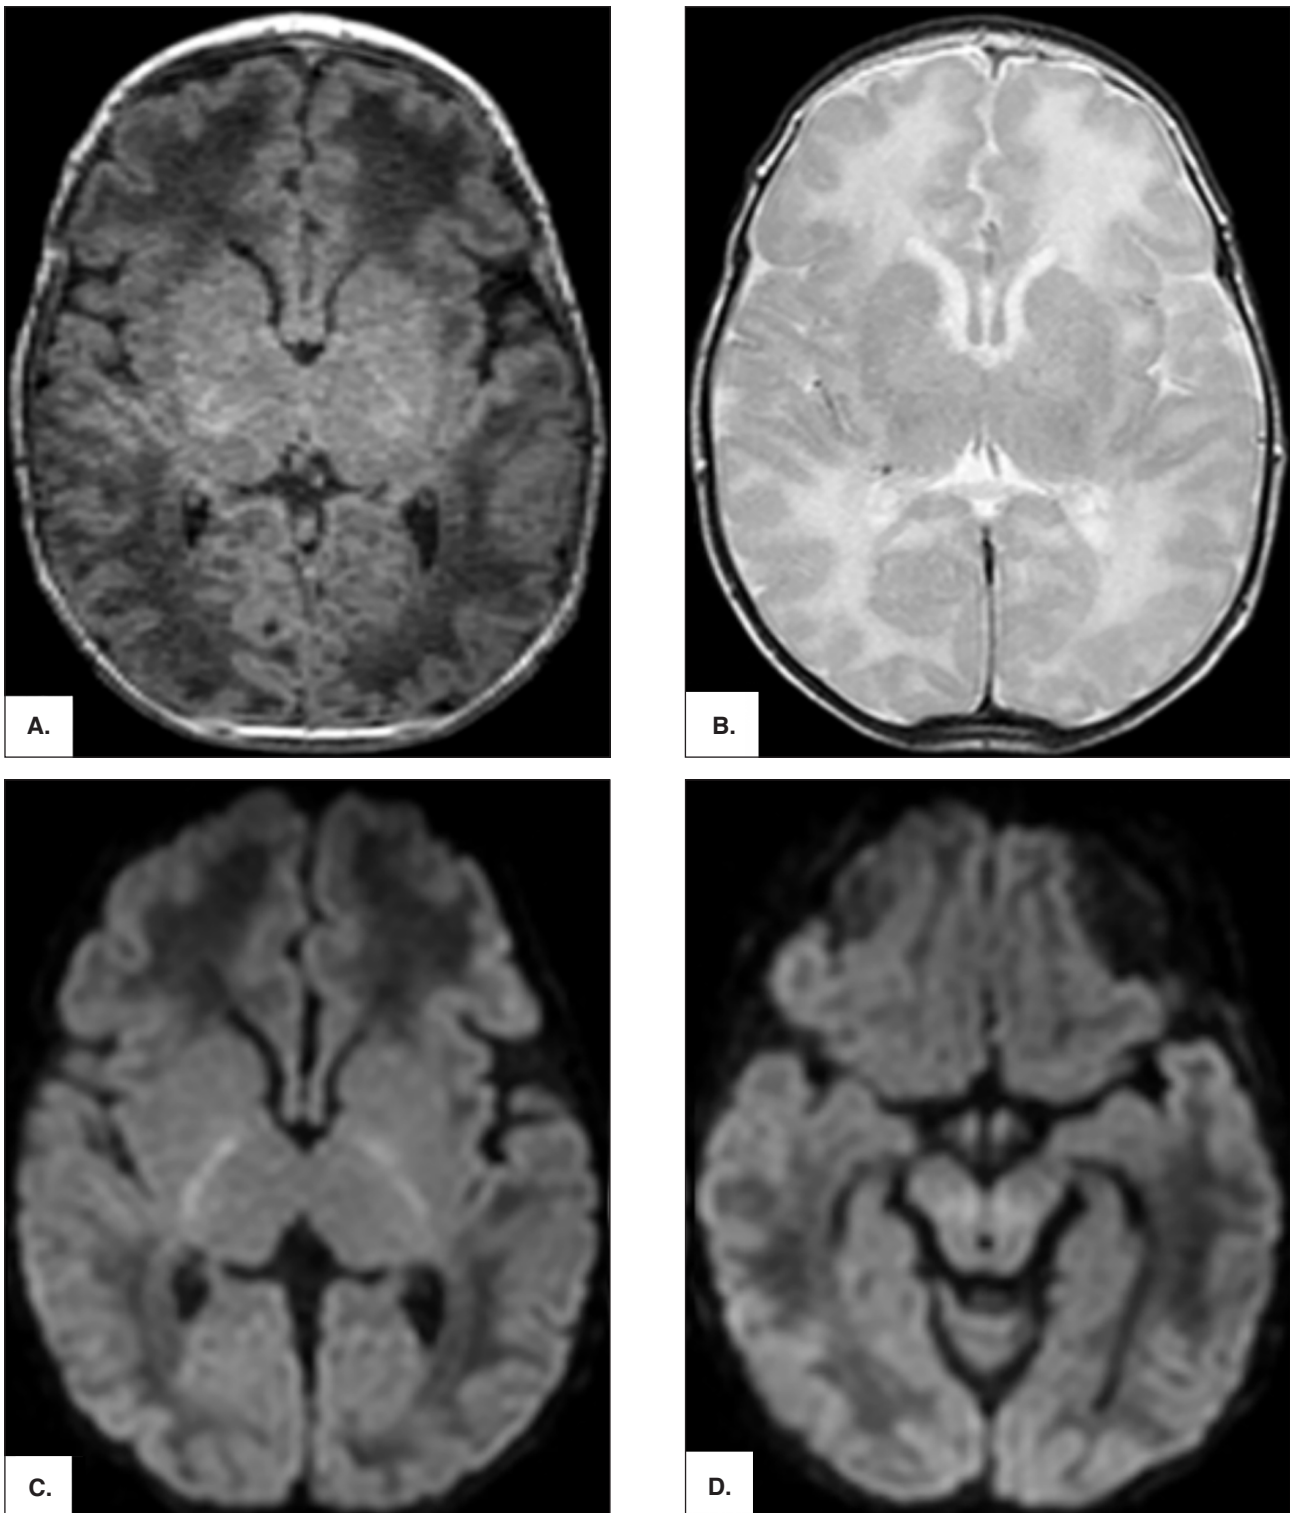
Magnetic resonance imaging (MRI) images revealing diffuse cerebral white matter edema (areas of hypointensity on T1 [A] with corresponding accentuation of hyperintensity on T2 [B]), and restriction to diffusion in the posterior arm of the internal capsules and dorsal region of the trunk (C and D).
